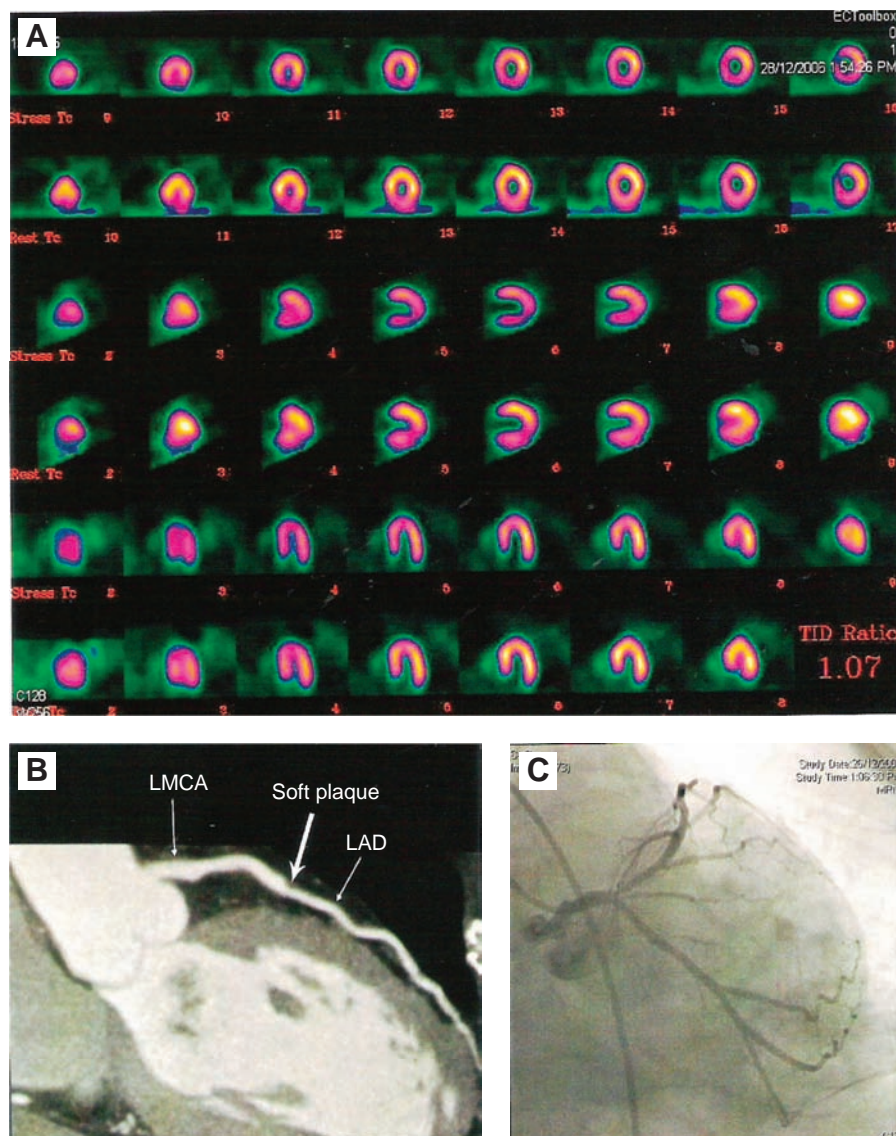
(A) Myocardial perfusion SPECT (MPS): Provocable ischaemia of anterior wall and apicoinferior wall. (B) CT angiography (CTA): Coronary artery calcium scoring (CACS) of 9, soft plaque in proximal LAD. (C) Coronary artery (CA): normal. CAG: coronary angiogram, LAD: left anterior descending, LMCA: left main coronary artery.
